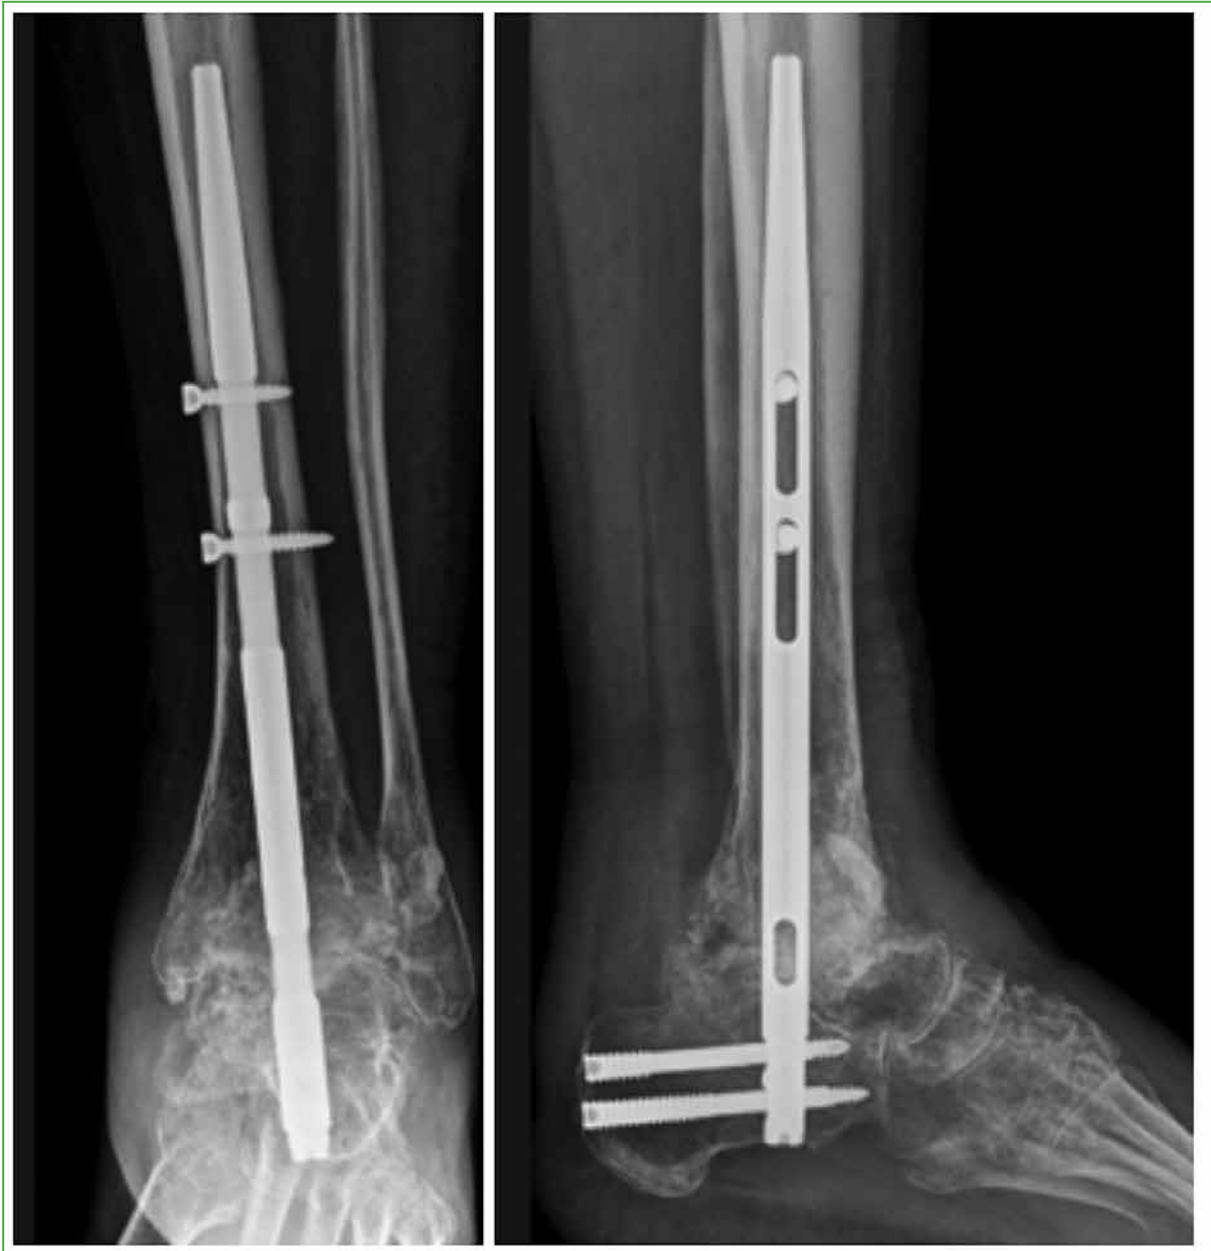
Anteroposterior and lateral ankle radiographs, one year after surgery. The consolidation and integration of the graft can be visualized.
